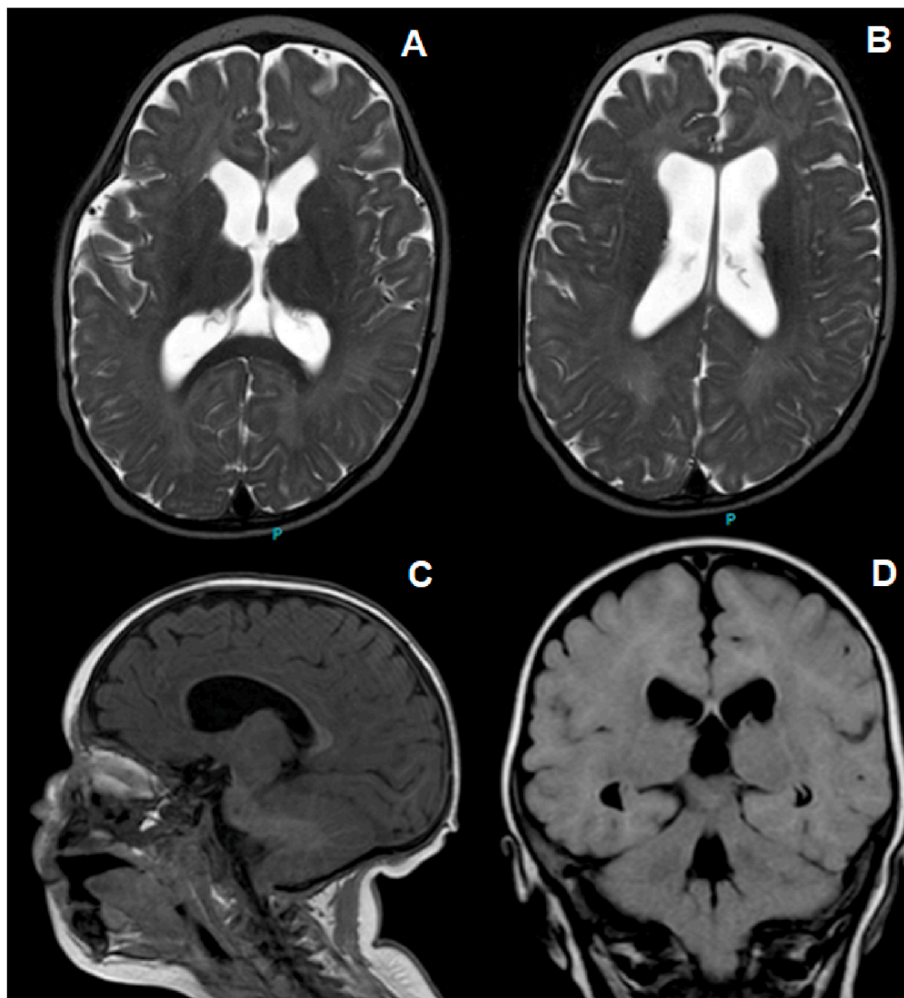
Cerebral MRI performed at 10 months of age. 1A and 1B: axial T2 weighed images, showing supratentorial ventriculomegaly and reduced white matter. 1C: sagittal T1 weighted images showing thin corpus callosum and tonsillar descent. 1D: 3D HR MRI displaying small posterior cranial fossa with partially narrowed fourth ventricle, wedge-like and descended cerebellar tonsils (Arnold Chiari type 1 malformation).
